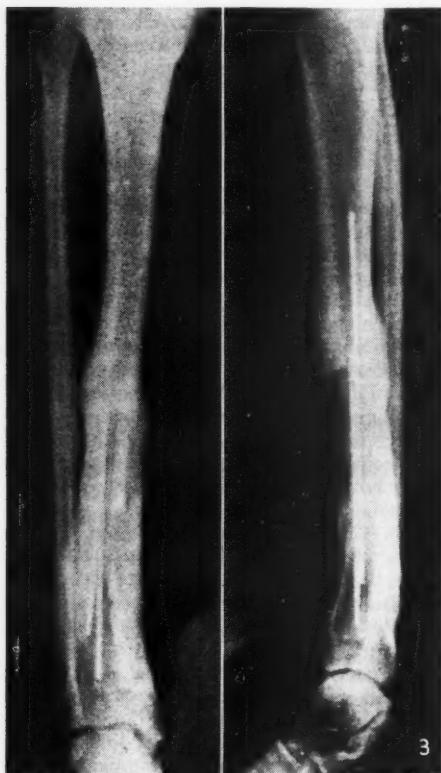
Two-year post-operative X-ray showing process of replacement of polyurethane by bone.
